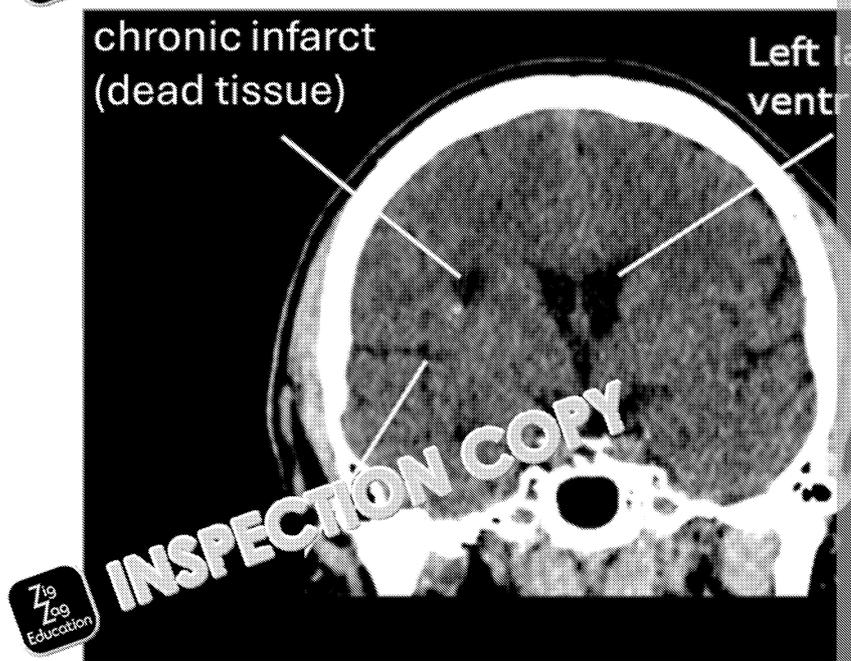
CT scan of brain showing a chronic infarct, as seen in a vertical section.
